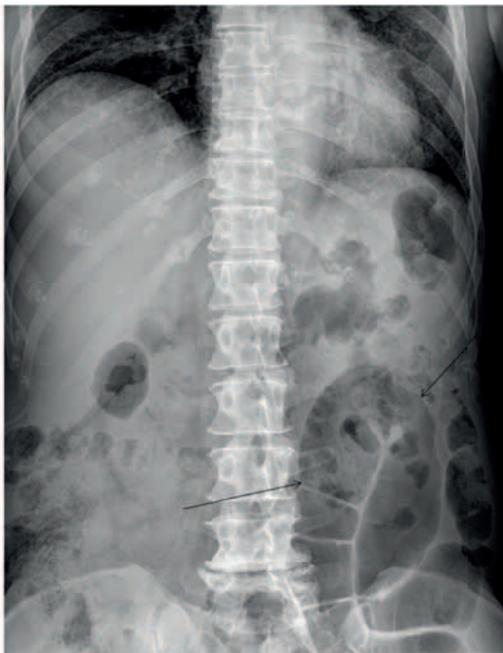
Native abdominal x-ray of patient with polymyositis showing dilated loops of small bowel without obstruction (arrows).
